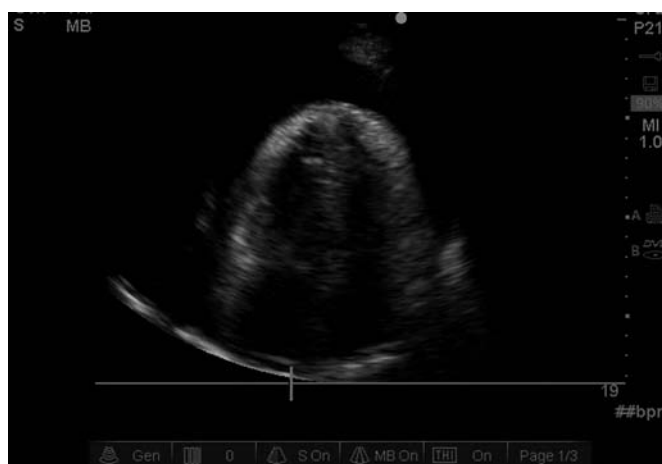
Apical four-chamber view of the heart.
